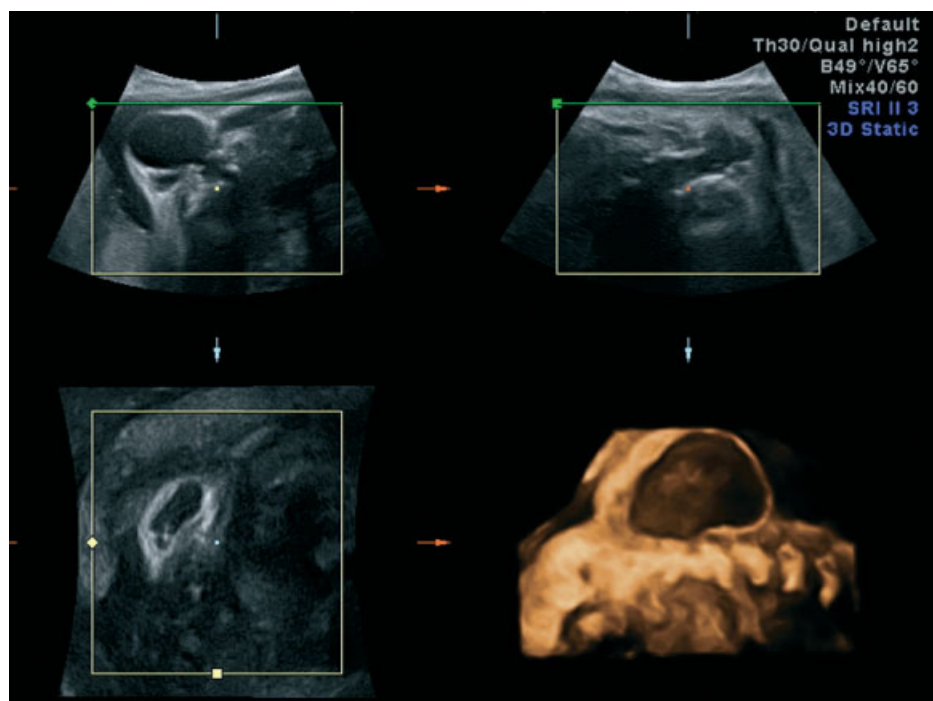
Multiplanar 3D ultrasound of meningocele. B-plane image (top left) shows continuation with spinal canal, A-plane image (top right) shows empty sac as does the surface rendered image (bottom right)
